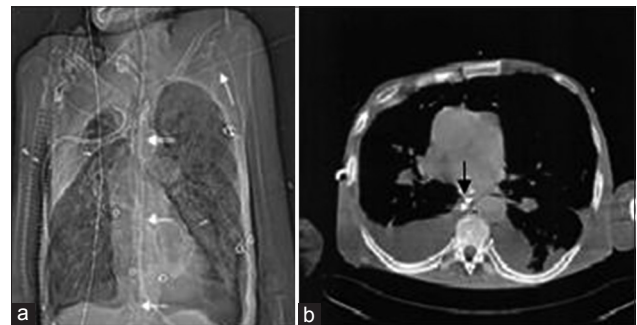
Catheter misplacement to the thoracic duct.^[44] (a) Scout view of the chest computed tomography shows the guidewire (arrows) takes a straight craniocaudal course projecting on the vertebral column reaching caudal to the diaphragm. (b) Computed tomography cross-sectional image at the level of the middle mediastinum. The guidewire (arrow) can be seen in a prevertebral position adjacent to the descending aorta and posterior to the esophagus.
